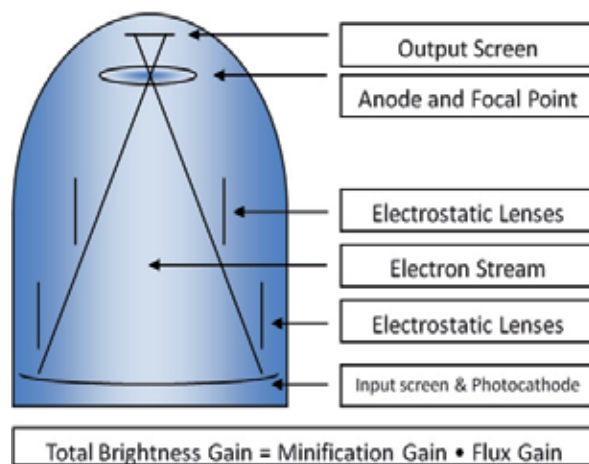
Inside the image intensifier tube, x-rays photons are converted to light photons at the input screen and then to electrons at the photocathode. Flowing through the image intensifier tube the electron stream is repelled by the negatively charged electrostatic lenses and is attracted to the positively charged anode. Electrons are converted back to light at the output screen in order to proceed to the image viewing system. The output quantity of light photons is significantly greater than the input quantity of x-ray photons due to total brightness gain.
